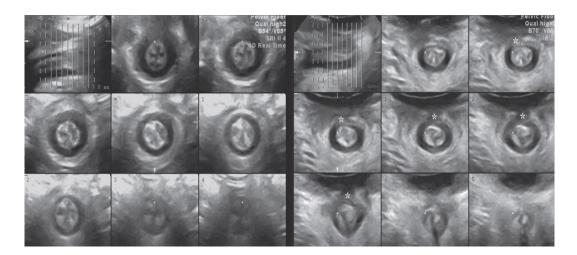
Translabial tomographic ultrasound imaging of the anal canal in a patient with clinically undiagnosed EAS trauma. The eight is cest demonstrating a circular structure show coronal plane representations of the distalliana canal. (a) shows an intact EAS at 38 weeks gestation, (b) a complete EAS tear (defects indicated by asterisk) in the same patient approximately 5 months later. There may also be IAS traumal in the top is cesting. The circular candidates a second degree per neal tear. EAS, external anal sphincter; IAS, internal anal sphincter. [Permission from Dietz HP. Nepean Medical School The University of Sydney]
